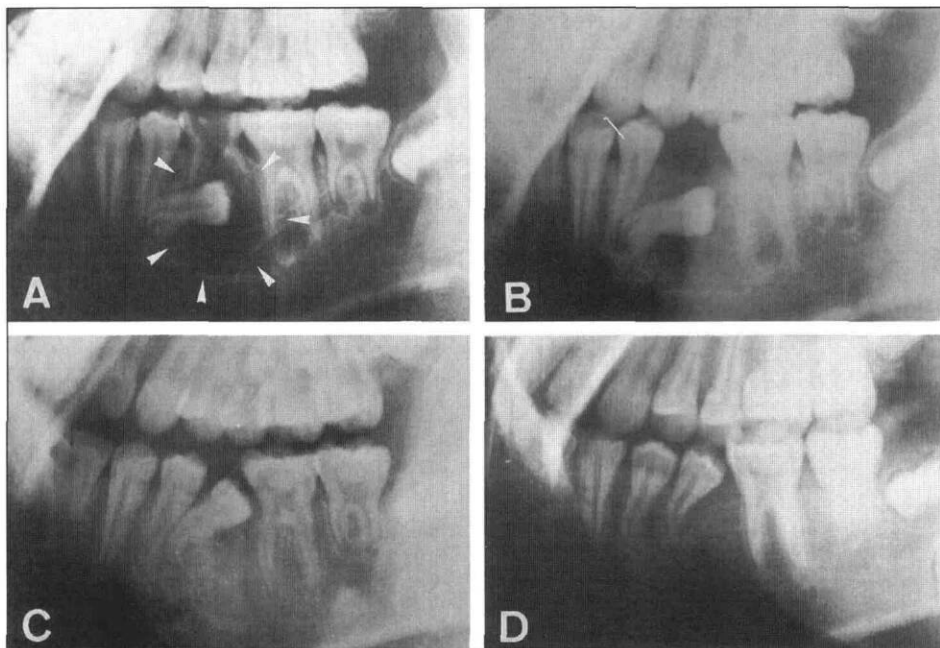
Lateral radiographs: a) On initial examination; b) 1 month after the operation; c) 5 months after the operation; d) About 1 year postoperatively.
